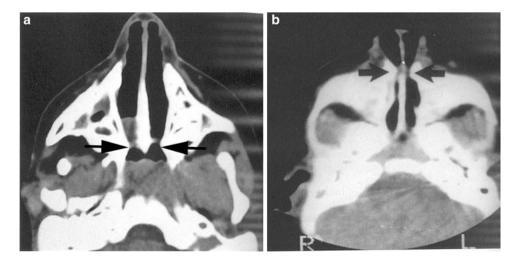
(a, b) CT scan of head showing: (a) Choanal atresia and (b) pyriform aperture stenosis. Note the differences in location of these embryologically different but similar clinical nasal obstructions. (Courtesy of Steve Sobol, CHOP Neonatal Airway Program)
